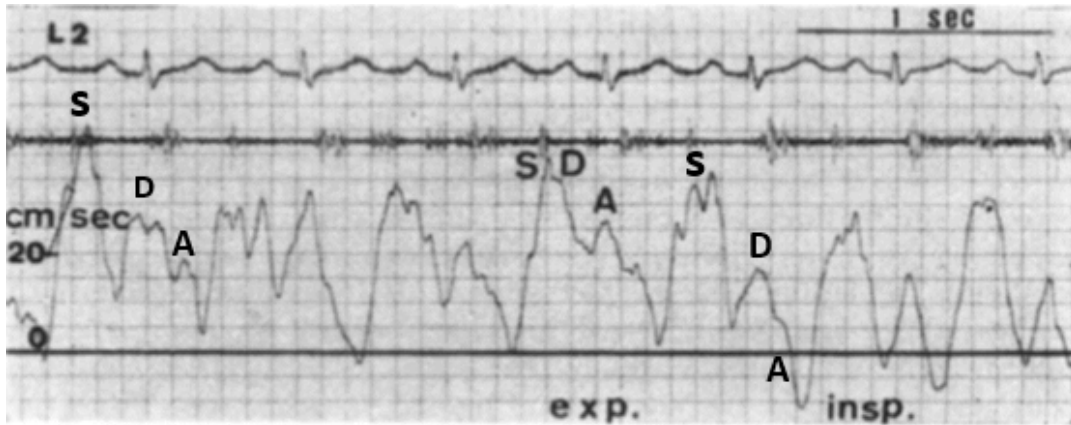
Flow velocity tracing of an atrial septal defect shunt, recorded by Doppler catheterization. The left-to-right shunt has three major components: S, late systolic and early diastolic, D, mid-diastolic, and A, end-diastolic. Some of the S and D wave are fused. The negative early systolic wave is present only during inspiration (two last complexes) which decreases the positive velocities, and increases the negative ones.
